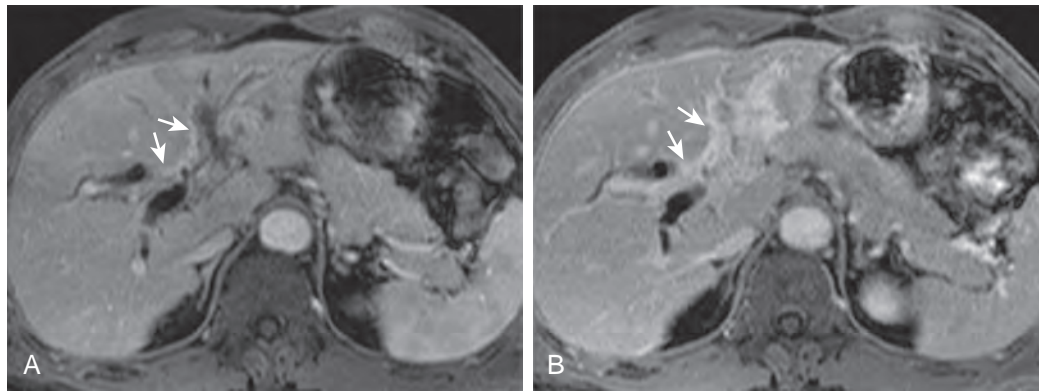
Delayed contrast enhancement of cholangiocarcinoma: MRI. A. Gadolinium-enhanced T1-weighted image obtained during portal venous phase shows an infiltrating hilar cholangiocarcinoma involving ductal bifurcation area and both main hepatic ducts (arrows). B. A 10-minute delayed T1-weighted MR image shows delayed enhancement of the mass (arrows). Tumor involves periportal fat with encased left portal vein.
